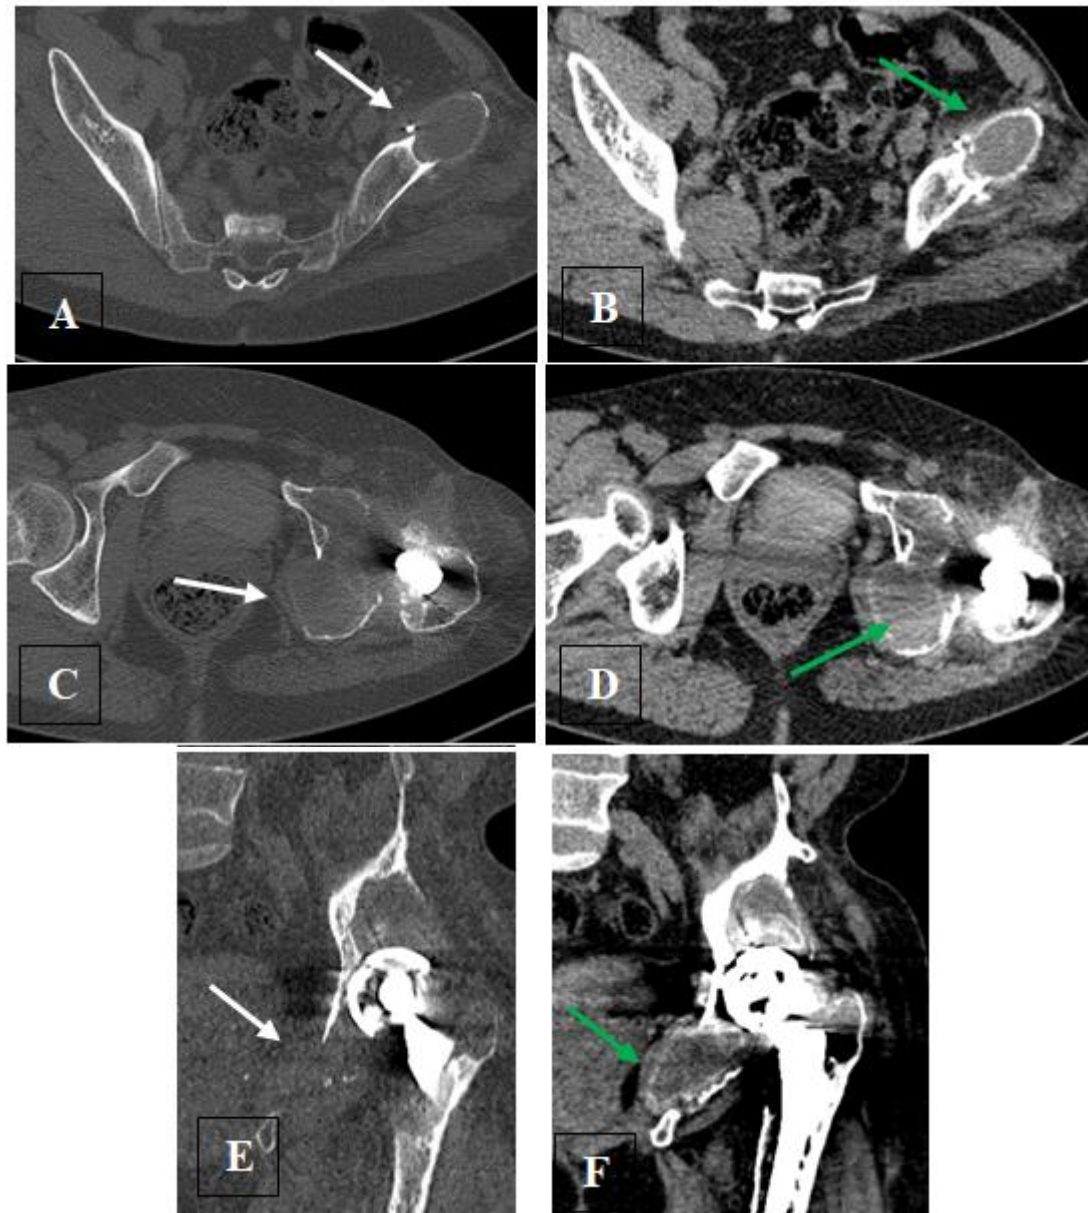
Axial (A,C) and coronal (E) CT images of the left hip in bone window, axial images (B,D) and coronal (F) non contrast pelvic CT scan images showing a osteolysis of the left iliac wing (white arrow in A), acetabulum with a completely destroyed medial wall (white arrow in C), and the ramus of ischium (white arrow in E). This bone matrix has been replaced by several round, fluid-filled pelvic periprosthetic collections surrounded by a high-density peripheral rims with the typical appearance of the « Bubble sign » (green arrows in B, D and F), which are located along the sites of capsulo-synovial insertions. Artifact from left hip prostheses is also present
